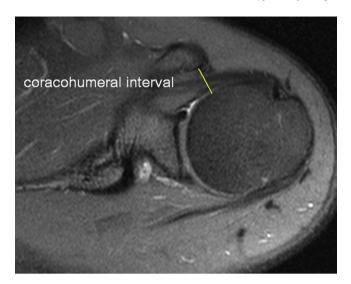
Coracohumeral distance was measured as the shortest distance between the outer cortices of the coracoid process and the adjacent lesser tuberosity on axial magnetic resonance imaging.
